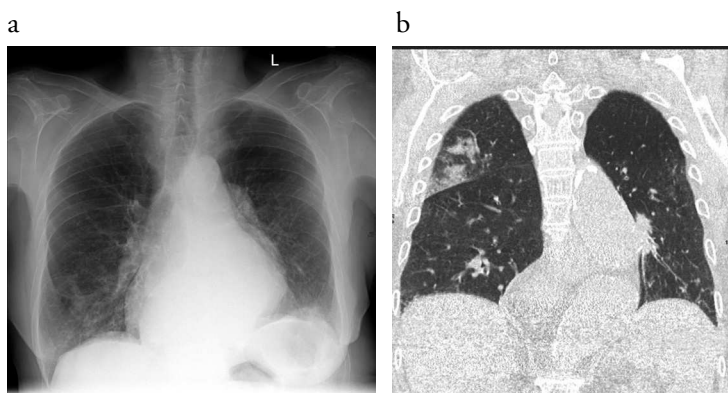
79 year old female was presented to our emergency room with symptoms of AE-COPD. a) Conventional chest X-ray without evidence of radiological abnormalities. b) Low-dose CT coronal plane of the same patients with alveolar consolidation of the right upper lobe.
